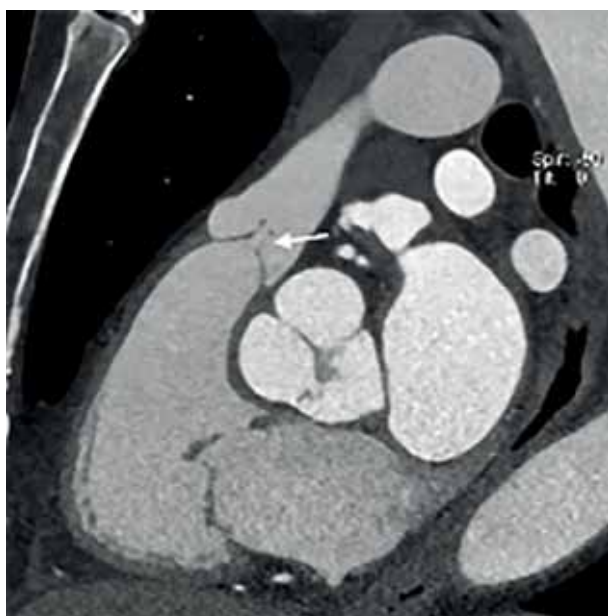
Cardiac computed tomography: multiplanar reconstructions at diastole, views centered on the pulmonary valve; severe thickening of the leaflets of the pulmonary valve with incomplete coaptation during diastole (the arrow)
